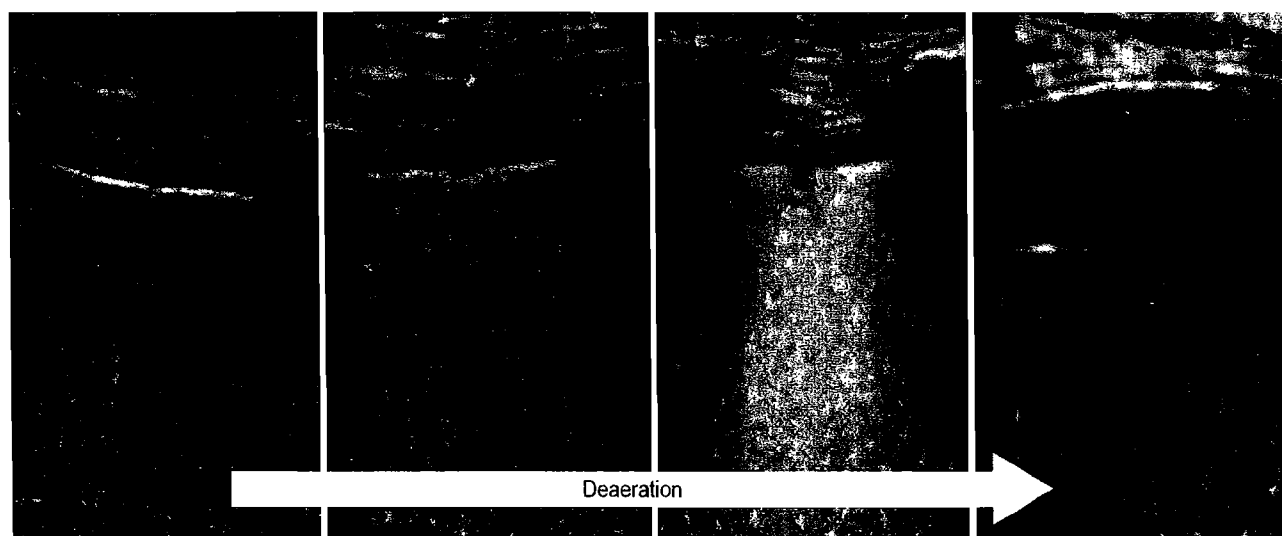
Ultrasound detection of changes in aeration pattern
